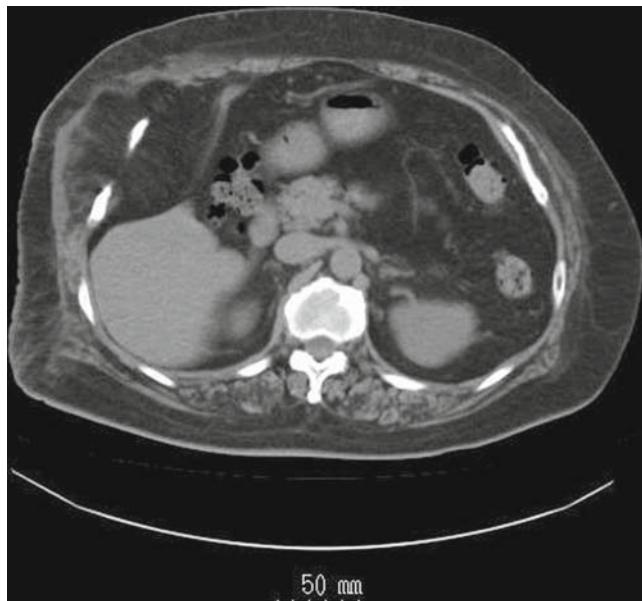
Case 2. CT scan shows a large, well-defined mass with low density in the right lateral chest involving the diaphragm and ribs
